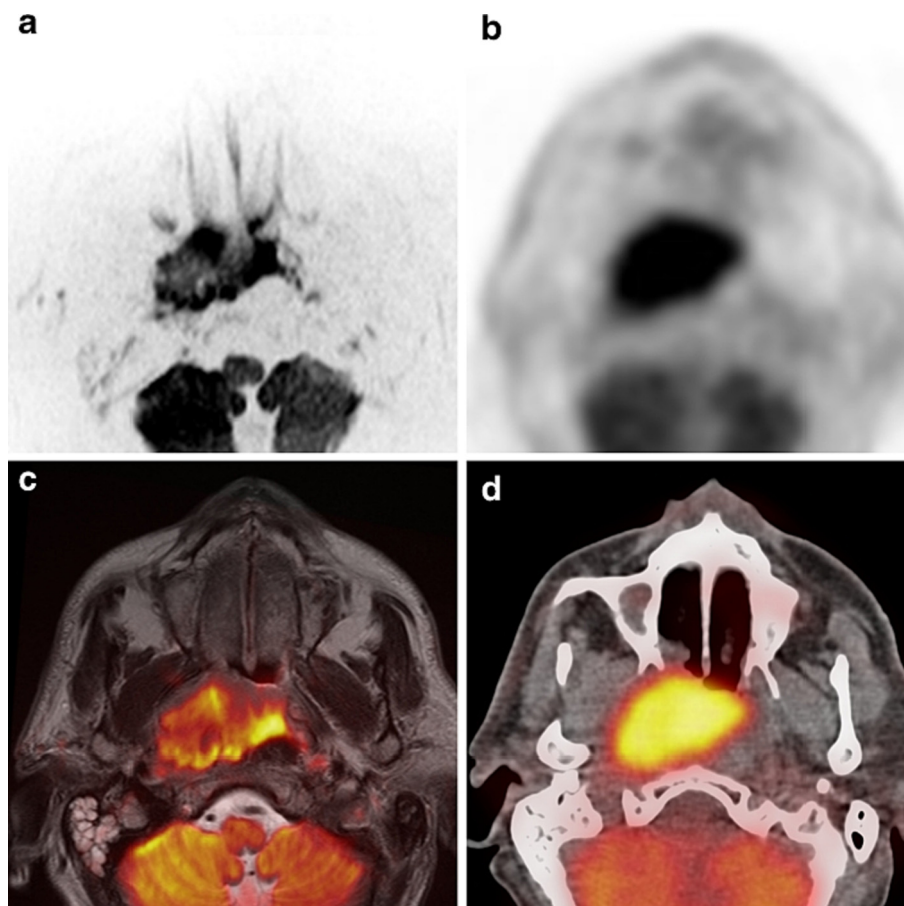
Image (d) is the fused image of PET scan and CT image for identification of right nasopharyngeal carcinoma (Varoquaux et al., 2013).
